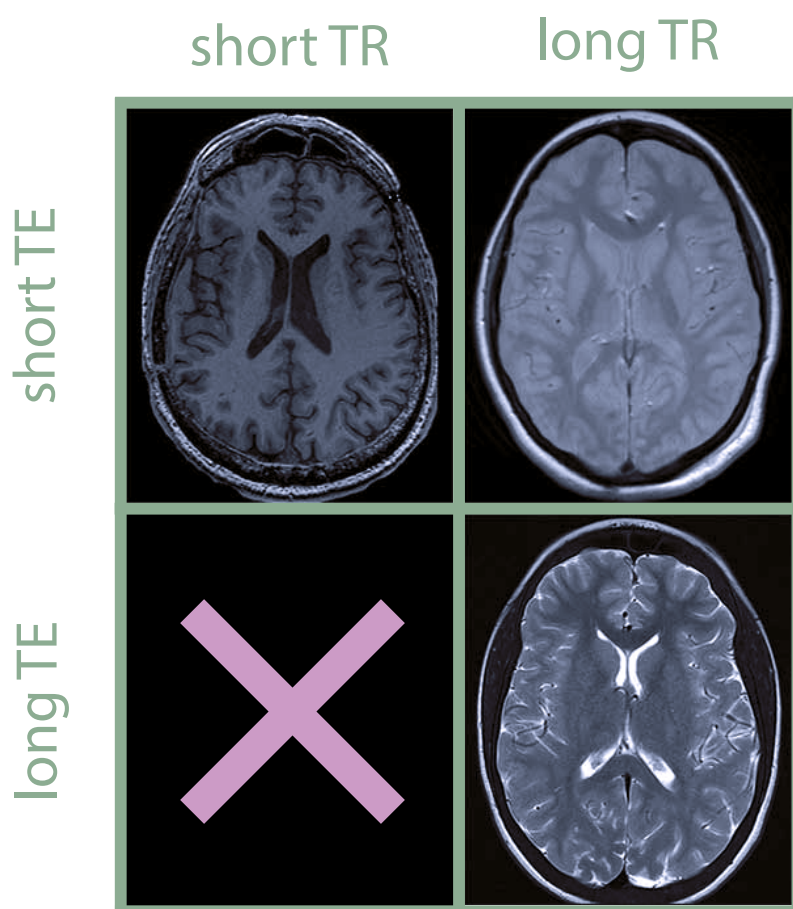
Relationship between time to echo (TE), repetition time (TR) and contrast of the MRI. With short values for TR and TE we get a  $T_1$ -weighted image (top left). Long TR and short TE, a proton-density-weighted image is generated (top right). Long TE and short TR produces images with very low contrast-to-noise ratio thus being useless. Finally, long TR and long TE, allows the scan of a  $T_2$ -weighted image (bottom right). In this context, “long” and “short” TR and TE are defined in relation to the  $T_1$  and  $T_2$  of the tissue we wish to image, respectively. Images adapted from [52].
